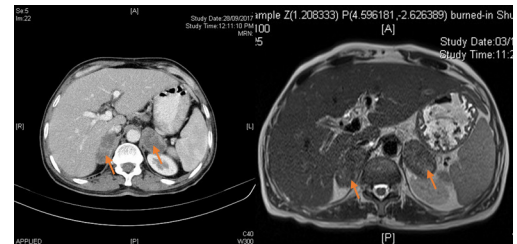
(L) A CT scan of the adrenal glands showing bilateral hypodense lesions with heterogeneous enhancement (shown with arrows); (R) MRI of the abdomen showing bilaterally enlarged, heterogeneously hypointense adrenal lesions (shown with arrows), measuring 30×22 mm and 36×21 mm on the right and left sides, respectively.
